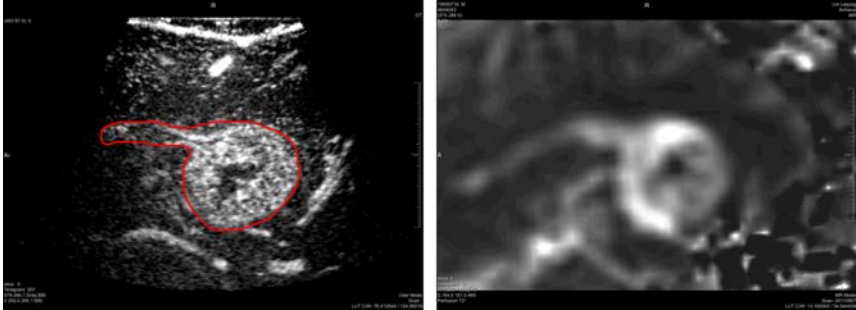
Registered intraoperative, contrast-enhanced Ultrasound (iUS) data (*left*) and preoperative MR perfusion data (*right*). The MR perfusion data has been resampled along the registered iUS image plane. The tumor margin is manually delineated in the iUS data and employed for registration as well as visualization purposes.
